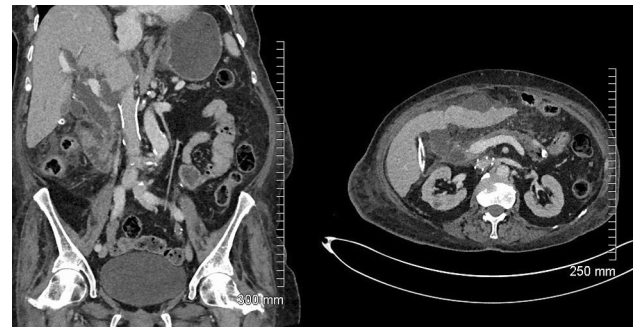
Coronal (left) and axial (right) CT images between 5 and 6 months later reveal interval bioconversion of the filter. The filter arms have been released and have retracted to the vessel wall leaving an unobstructed lumen
